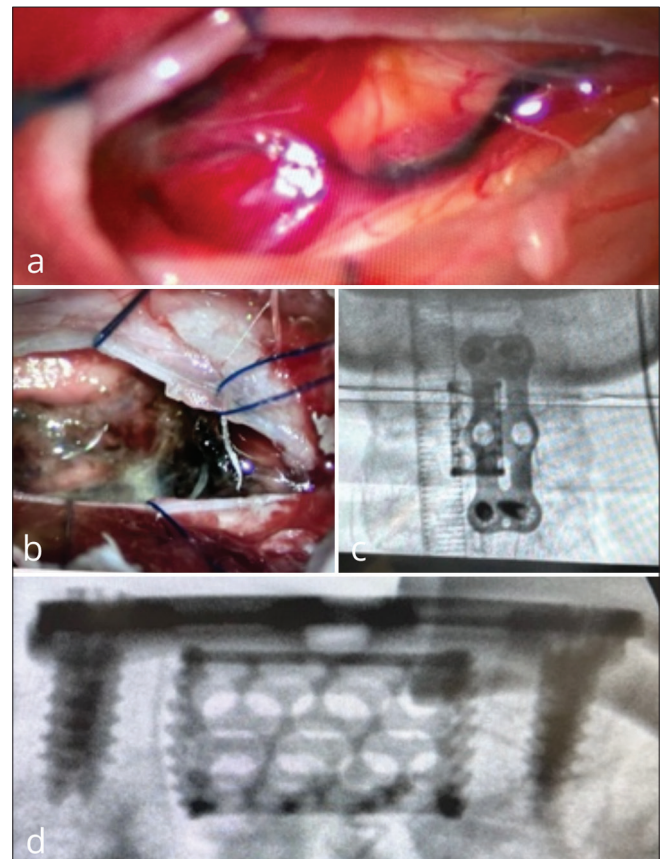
Direct occlusion of the low cervical, ventral, spinal dural fistula. (a) shows anterior cervical approach, and (b) shows the C5 corpectomy. In postoperative anteroposterior (c) and lateral (d) X-ray views, the interbody spacer and the anterior lordotic plate are seen.
